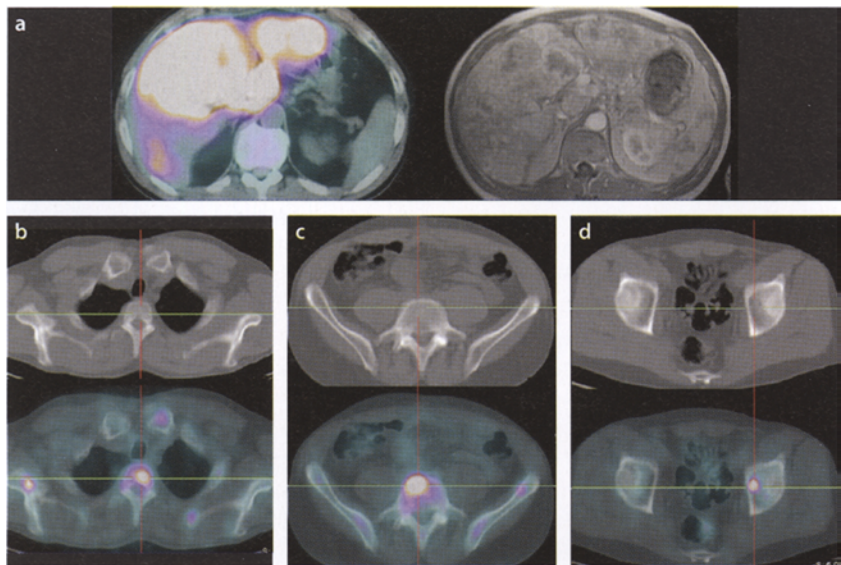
Same patient as described in Figure 18.3. Extensive, bilobar liver metastases (a) as shown by F-18 FDG-PET/CT (upper left row, highest glucose metabolism in segment VII with an standard uptake value (SUV) of 29.1) and MRI (upper right image). Hypermetabolic bone metastases are detected by FDG-PET in the thoracic spine and in the right scapula (b), in the lumbar spine in L5 (c), and in the left acetabulum (d), whereas the CT scan is still normal (i.e., the lesions are located mainly in the bone marrow)
